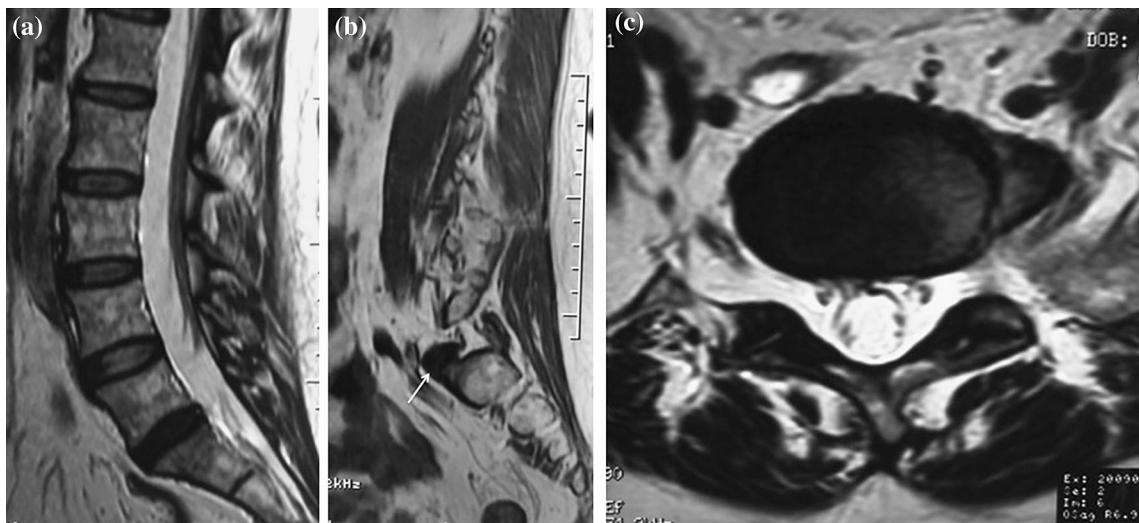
MRI showing L5S1 discopathy (a) with a large lateral disc extrusion on the *left side* (b white arrow, c)
